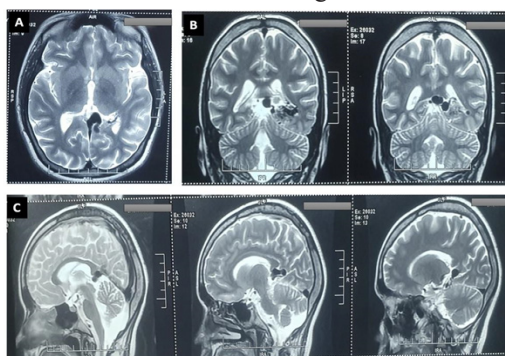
Pre operative MRI images
